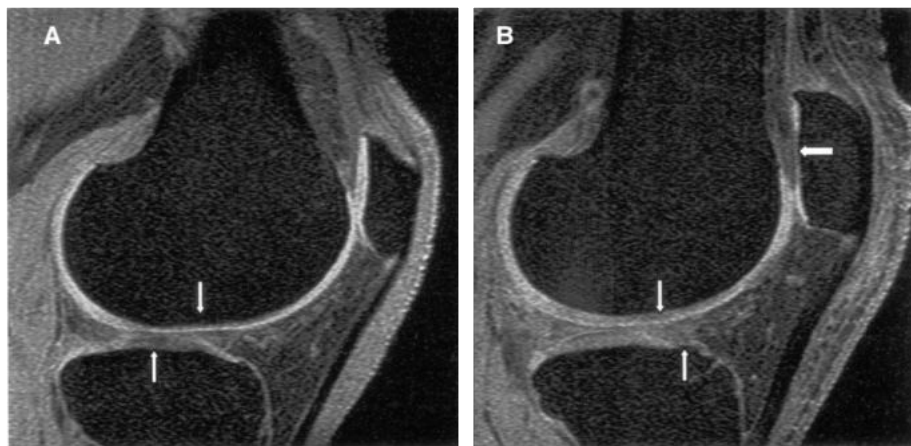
Quantitative 3-dimension (3D) analysis of cartilage morphology from MRI
